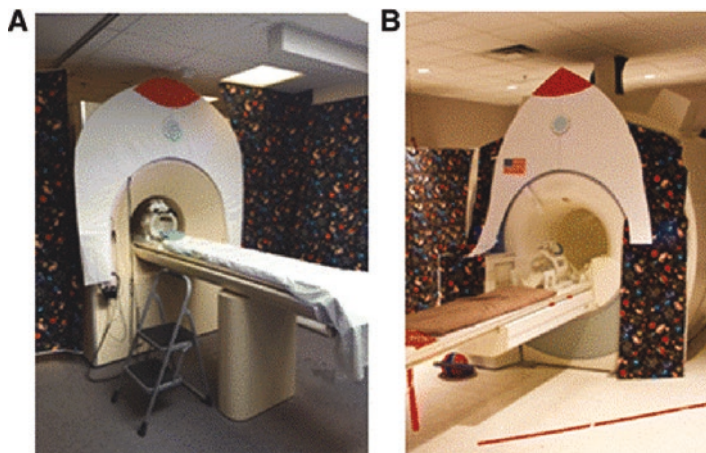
A pediatric-friendly space theme environment for (a) mock MRI scanner and (b) 3 T MRI scanner. (Reproduced from Nordahl et al., 2016)
